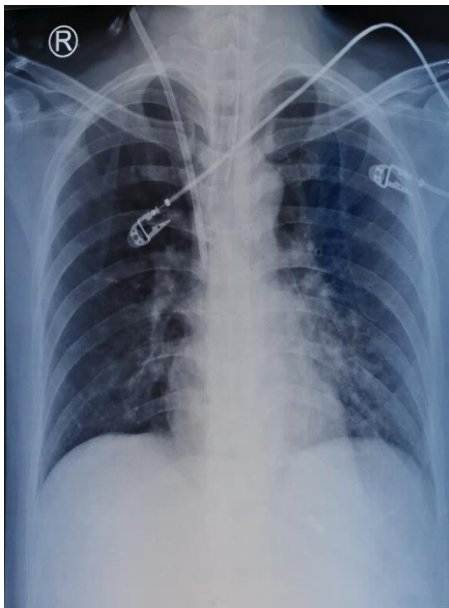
Chest X-ray on the 8th day in ICU
